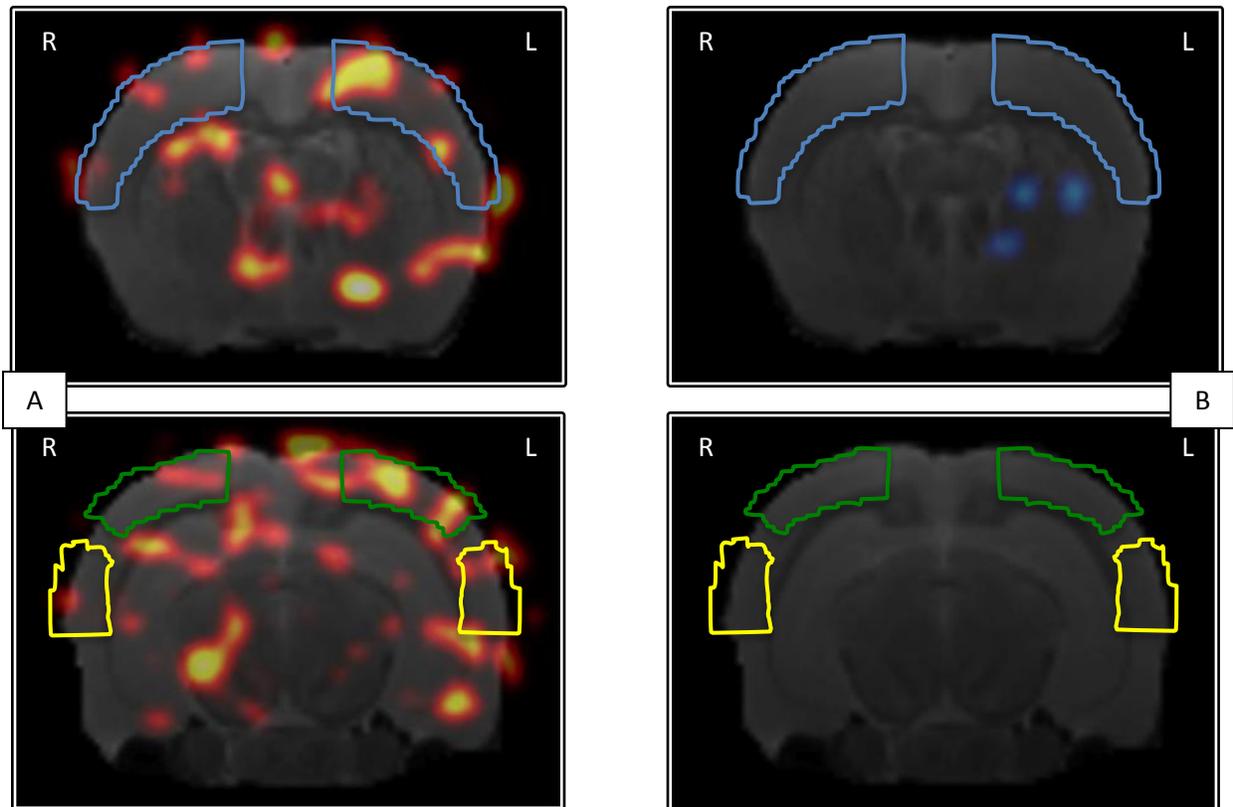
PET-FDG image of the sensory regions.
